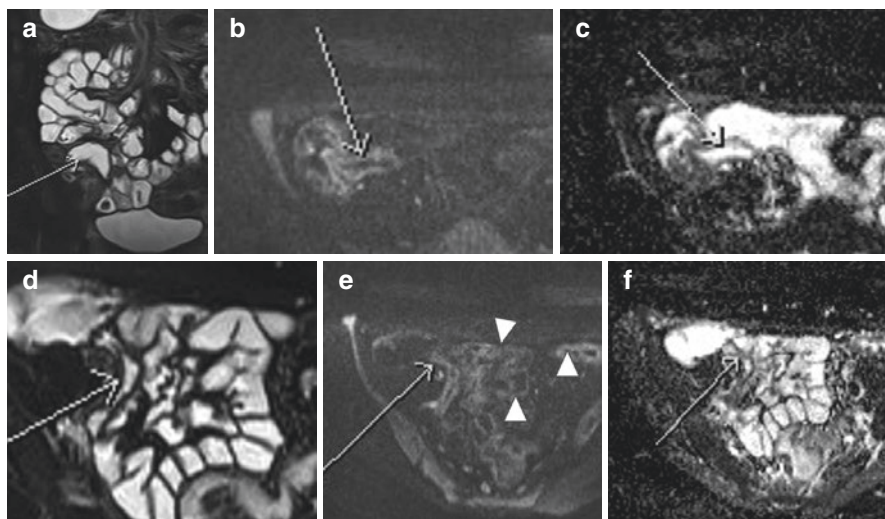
Changes in DWI following treatment. There is a mildly thickened and active terminal ileal activity in a Crohn's patient, on coronal HASTE with fat saturation (a) and DWI (b), with mildly restricted diffusion on the ADC map (c). Subsequent follow-up on treatment 1 year later (d–f) still demonstrates some mild mural thickening, but the degree of restricted diffusion has improved to the level of adjacent/background bowel activity (arrows)
